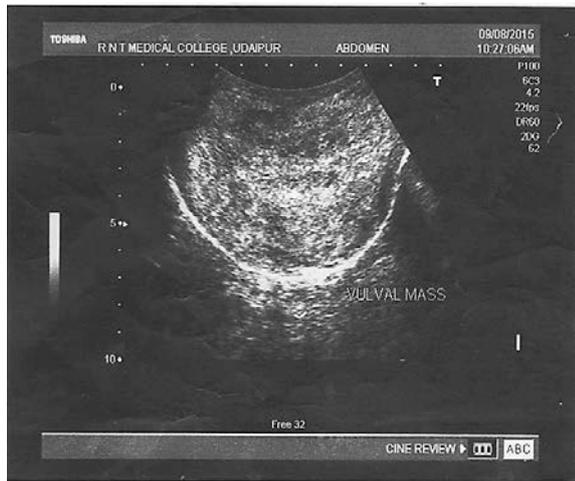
Ultrasound image showing vulvar mass around 9\*8 \*7 cm
